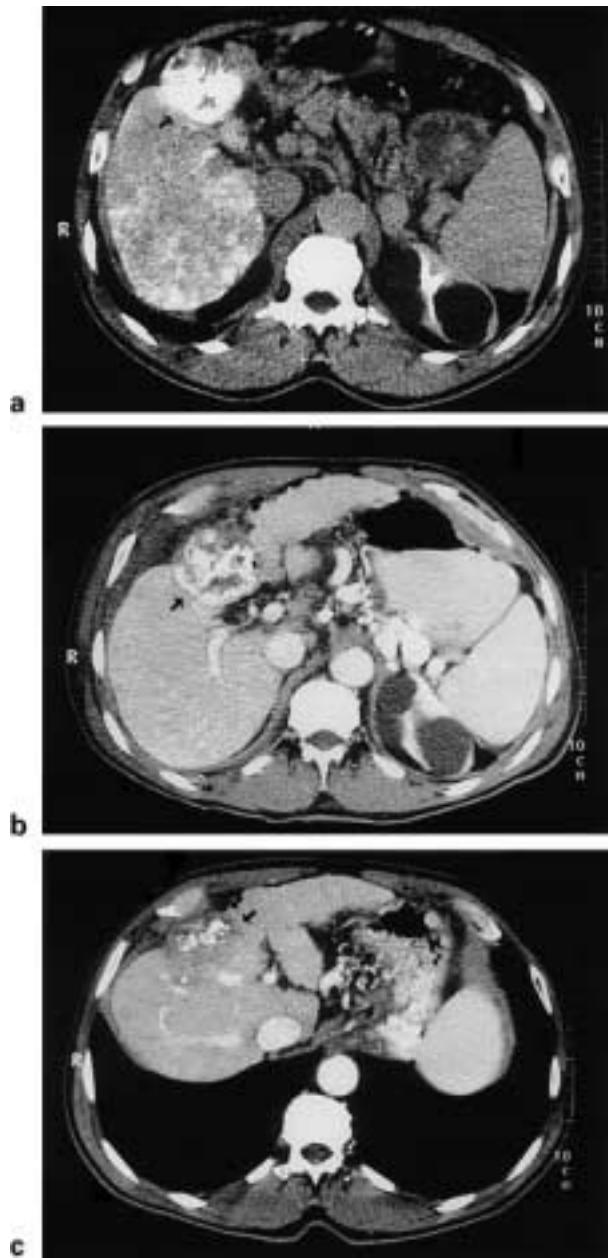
Contrast-enhanced computed tomogram a before, b 1 day after and c 7 months after laser treatment of a 4.5-cm large hepatocellular carcinoma in the anterior sector of segment four (arrow). Because of cirrhosis, portal flow was negligible during treatment (four fibres with diffusing tips of 5 cm). Through these fibres 12.5 W of neodymium yttrium-aluminium-garnet light per fibre was guided simultaneously over 6 min (4500 J per fibre). In b and c laser-induced avascularity is seen. In c a small enhancing rim (double arrow) indicates incomplete tumour destruction (a second laser treatment was scheduled)
